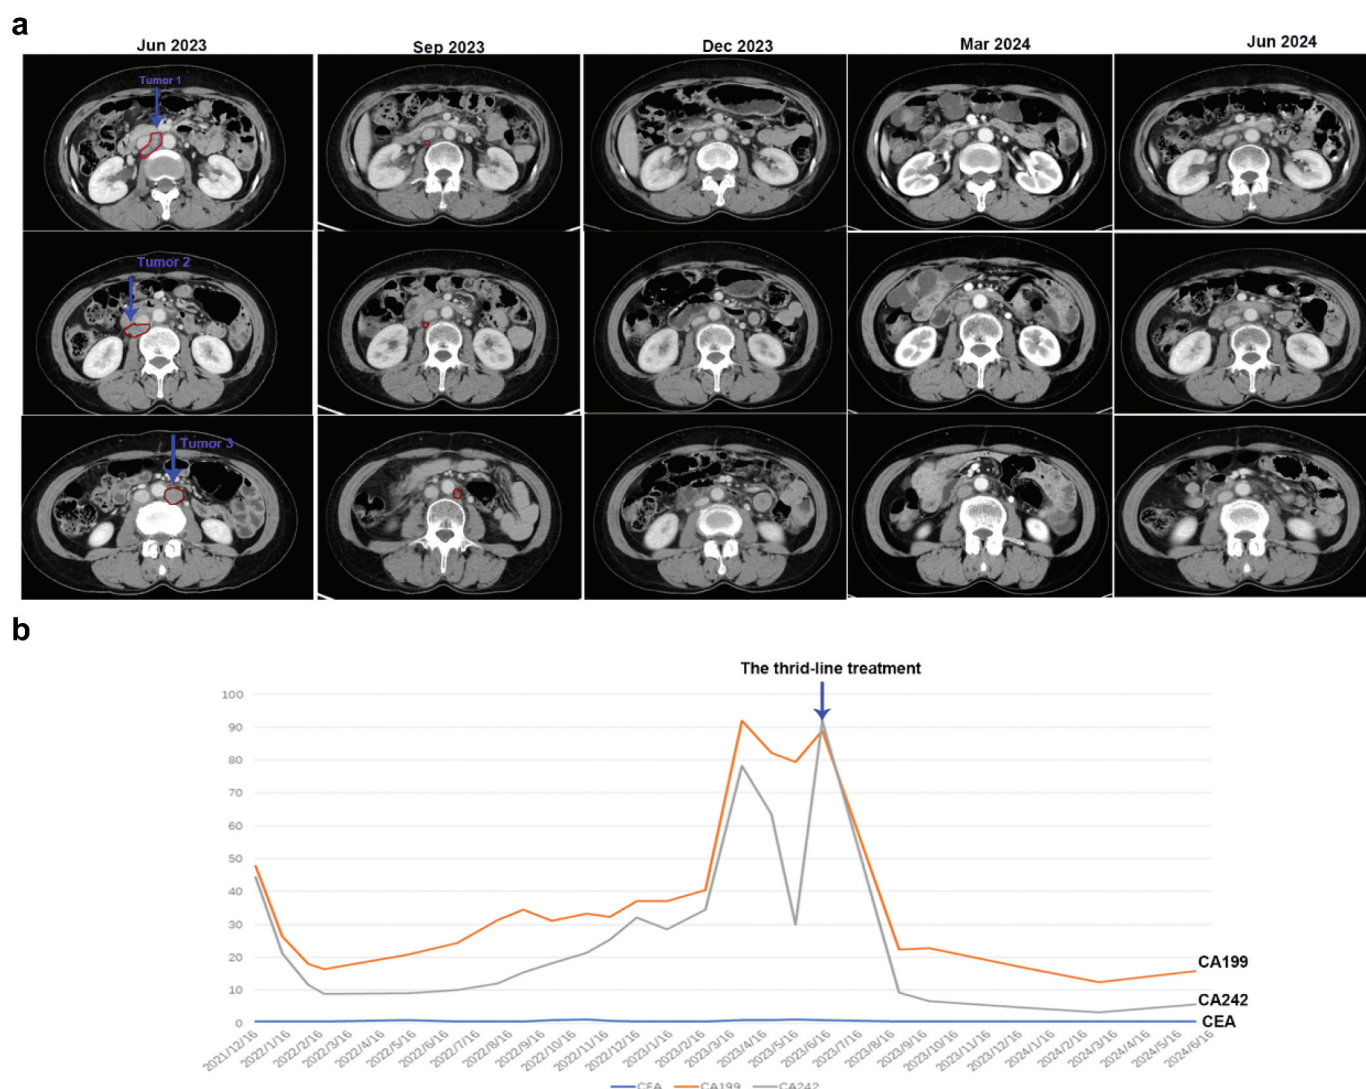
(a) Comparison of CT images of abdominal para-aortic lymph node metastasis before (June 2023) and after third-line treatment (Sep 2023 to June 2024). (b) Comparison of the expression levels of tumor markers including CEA, CA199, and CA242 before and after the third-line treatment.
